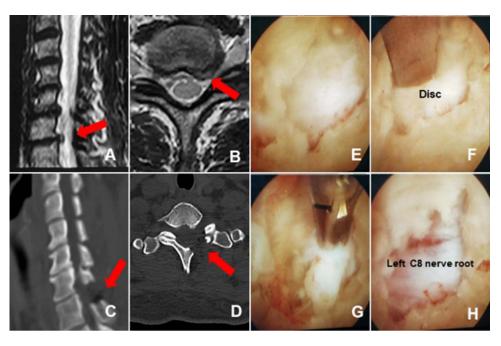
Figure I (A) 49-year-old female patient who suffered from radiating pain and motor weakness in the left upper extremity that had occurred 3 months previously. (A and B) Images of preoperative magnetic resonance imaging (MRI) demonstrating left C7–TI foraminal encroachment of the herniated intervertebral disc, red arrows point to the protruding nucleus pulposus and the compressed nerve root. (C) and (D) A well-decompressed state was confirmed by computed Tomography (CT) at 3 days postoperatively, red arrows point to the postoperative lamina structure and decompressed nerve roots. (E) and (F) Intraoperative endoscopic finding of the extruded disc which compressing the left C8 nerve root. Intraoperative endoscopic finding during discectomy (G) and after discectomy (H).
